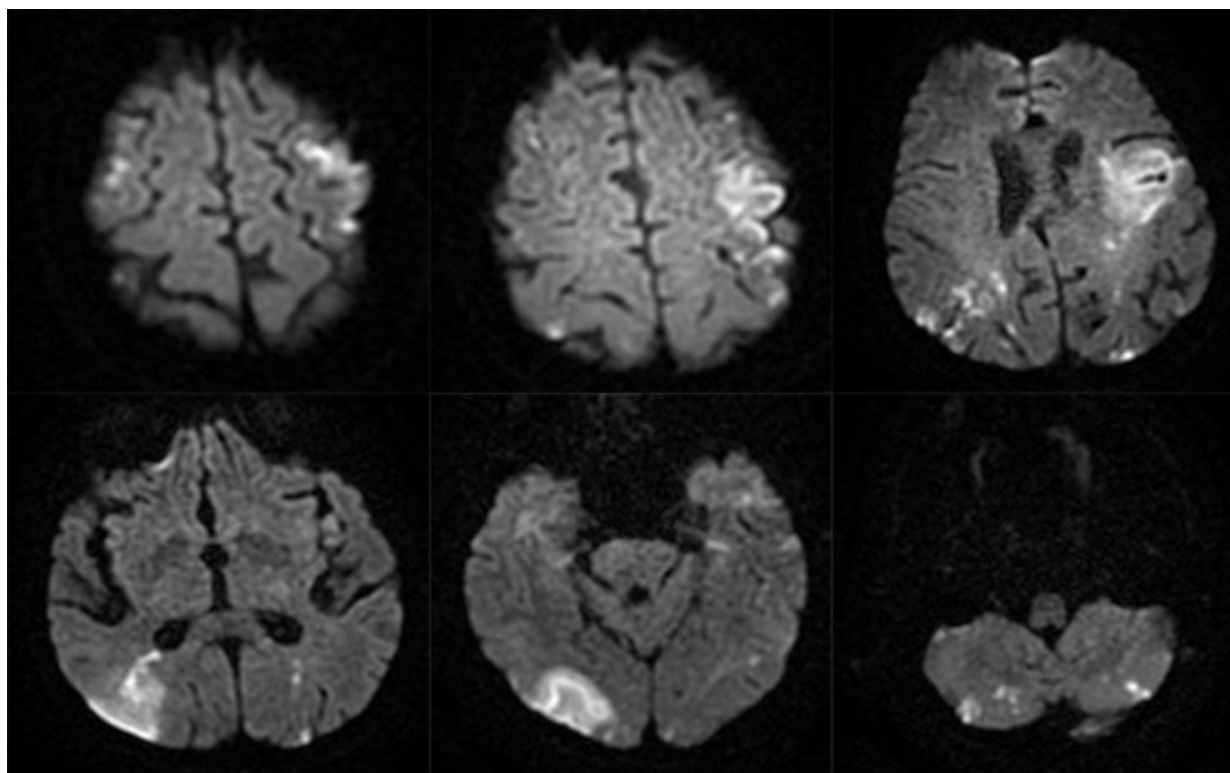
Cranial diffusion magnetic resonance imaging
